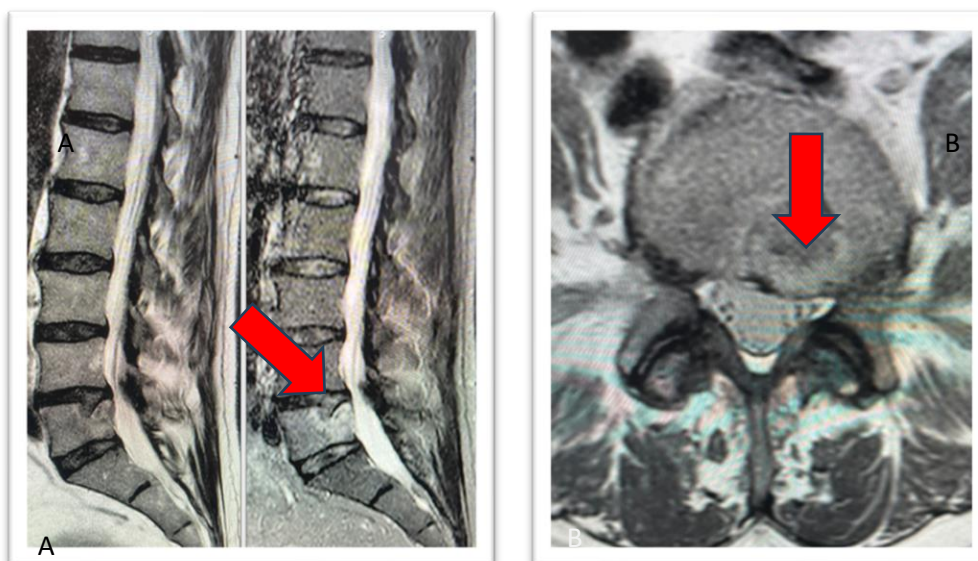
A-B: sagittal and axial MRI of the lumbar spine: an area of altered signal intensity involves the left hemibody of L5 (arrows).
